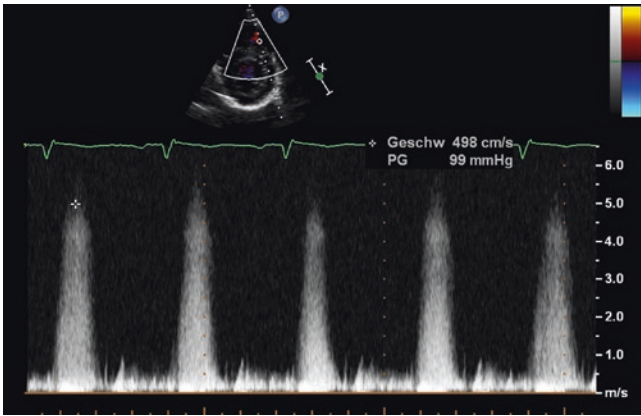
Continuous wave Doppler in a patient with restrictive muscular VSD measures a maximal flow velocity of 4.98 m/s. According to the simplified Bernoulli equation, this represents a systolic pressure gradient of 99 mmHg between the left and right ventricle
